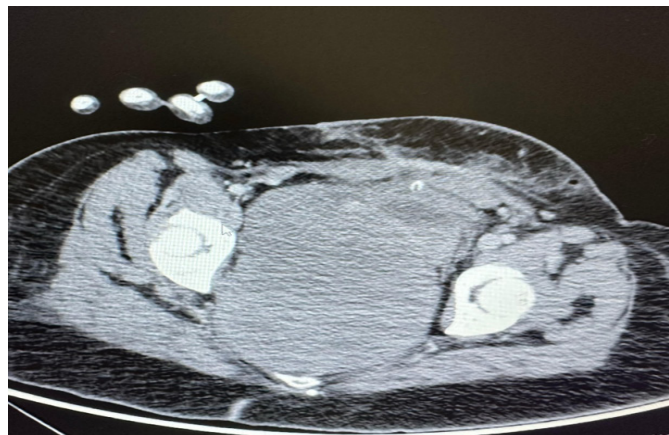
Heterogeneous pelvic mass with uterus within the pelvic bone borders on computed tomography
